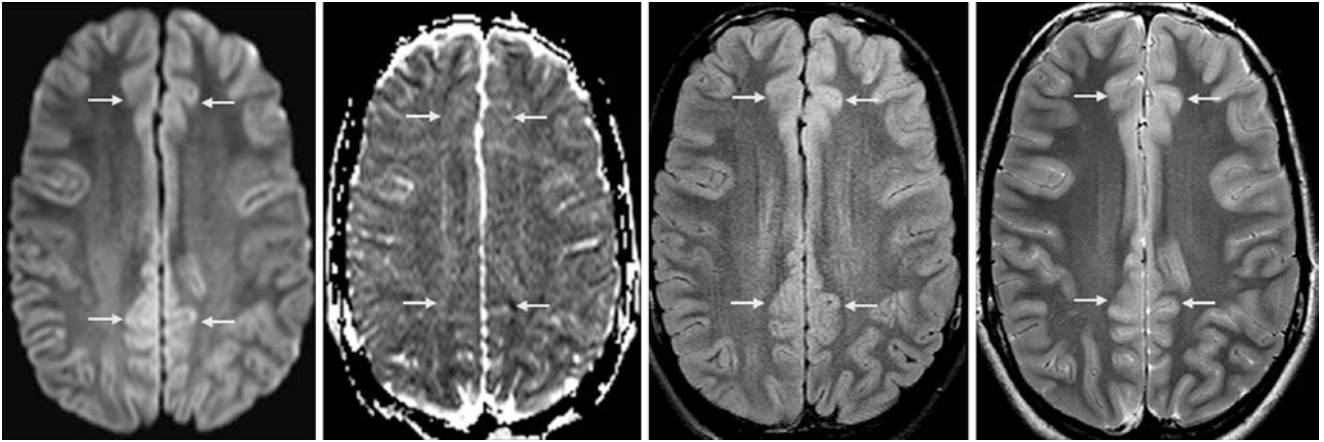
A 16-year-old with headaches had a 3 T MRI that shows normal, multifocal cortical hyperintensity on DWI (*left*), FLAIR (*right middle*), and T2WI (*right*), particularly in the cingulate gyri and frontal
